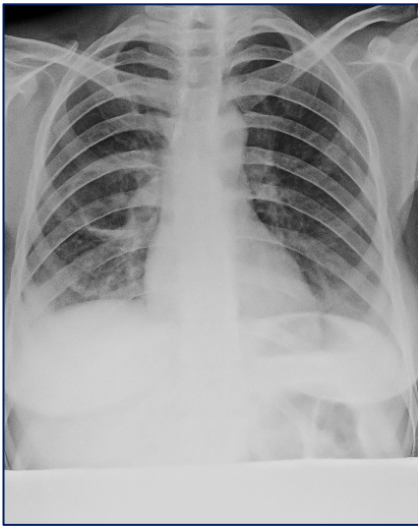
Chest X-ray PA view with abdominal guard to avoid fetal radiation exposure shown cavity in right mid zone
